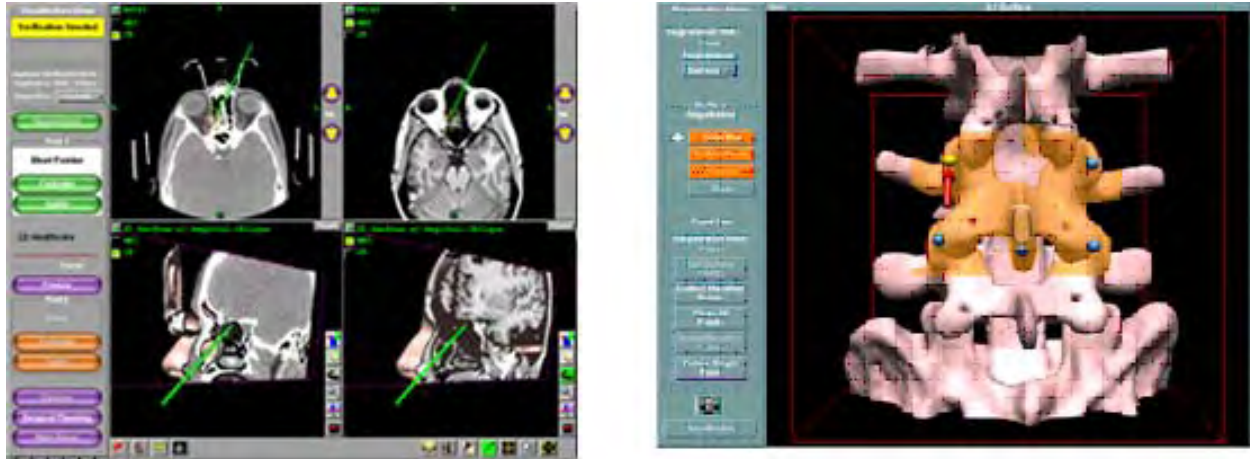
(A) CT/MR registration of the head and brain; (B) CT paired-point registration of the spine.
